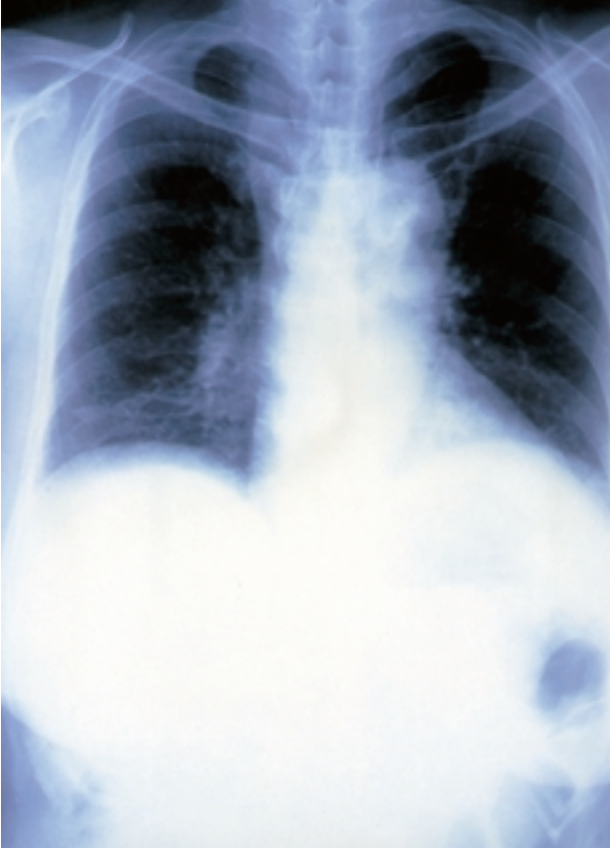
Chest radiography shows a 2-cm noncalcified solitary pulmonary nodule in the right lower lobe.
